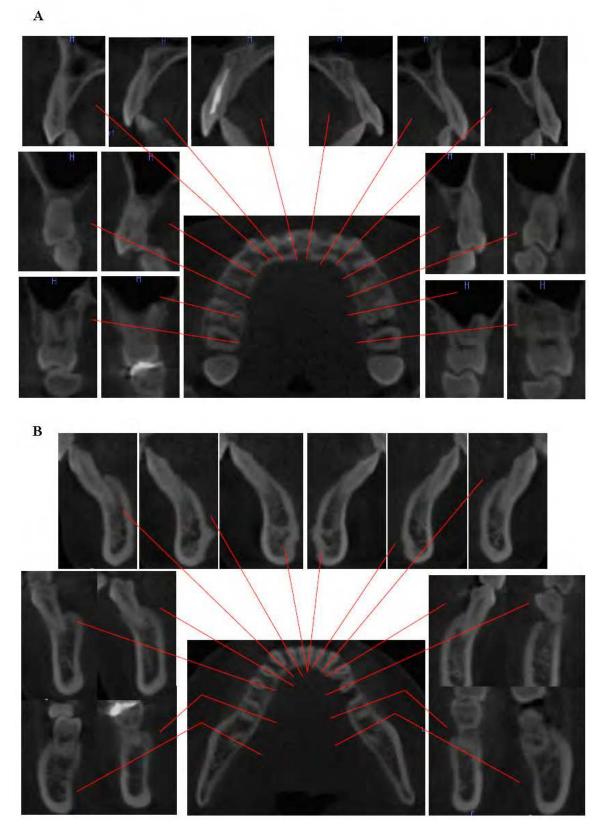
Cone-beam X-ray computed tomography (CBCT) images of the upper arch in preorthodontic treatment (A) and CBCT images of the lower arch in pre-orthodontic treatment (B).
